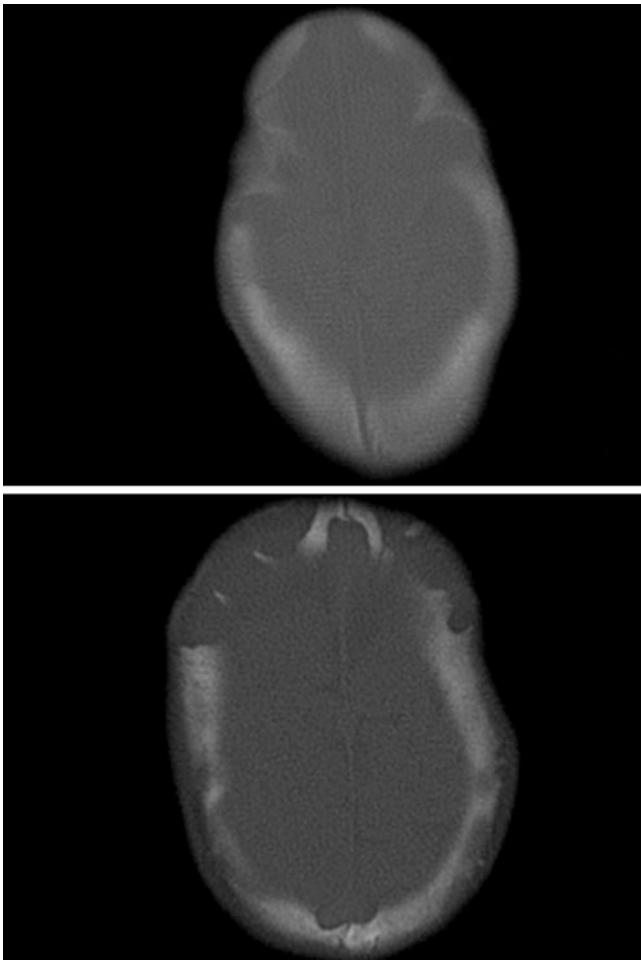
Comparison case: craniosynostosis, scaphocephaly, and hydrocephalus are present on a CT in a 3 month old (*top*). The honeycomb-lacunar skull (craniolacunae) became more prominent at 9 months (*bottom*)
